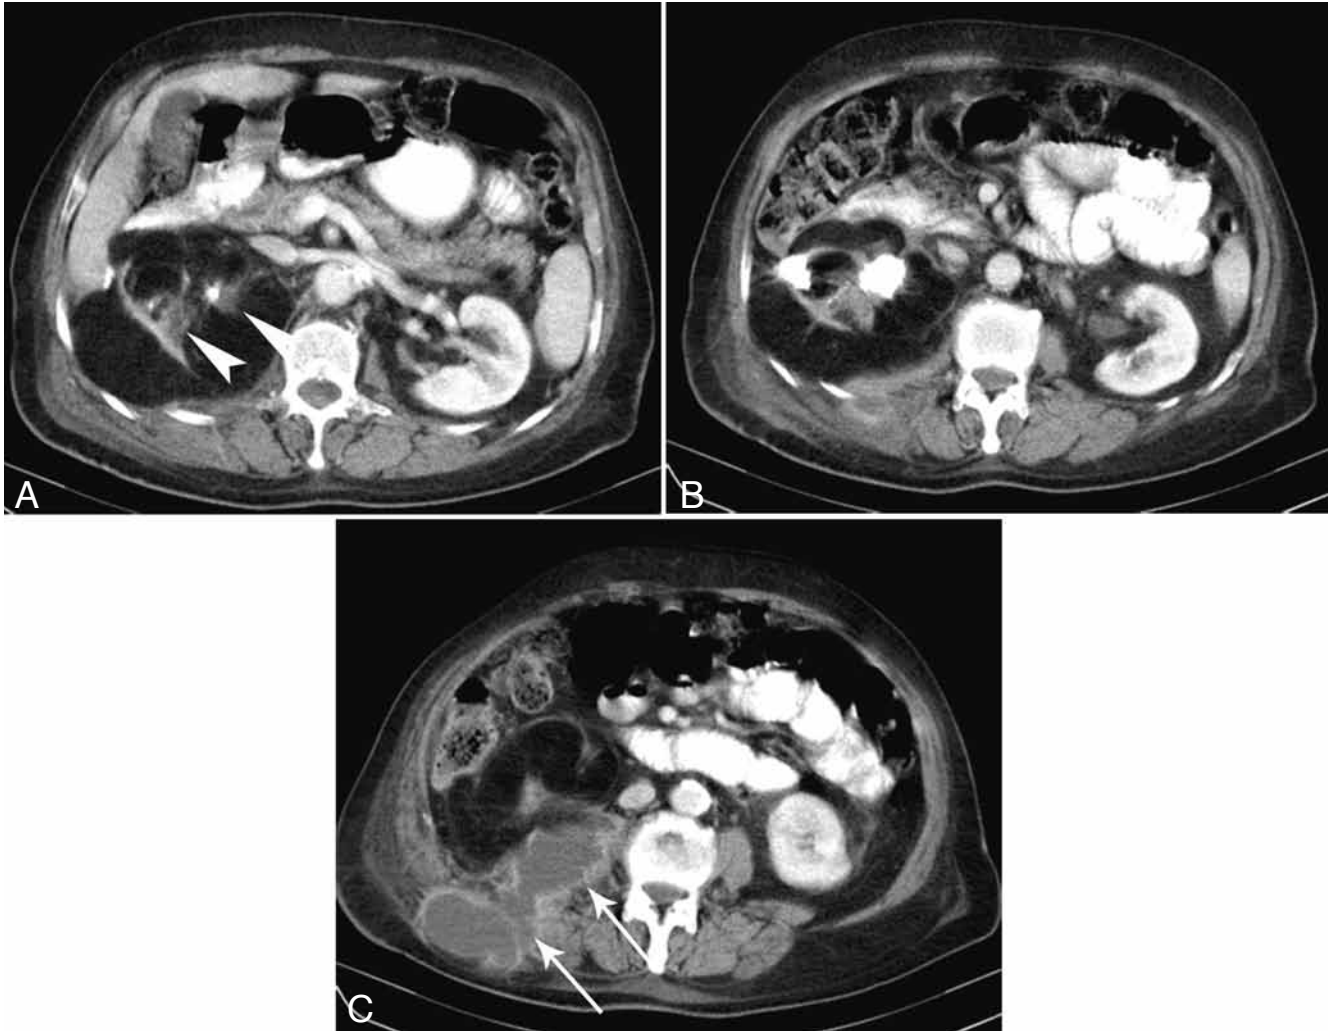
Axial CT image showing significant fatty proliferation of the right renal sinus, hilus, and perirenal space, focal low-density areas (arrowheads) and advanced parenchymal atrophy (A). Central areas of high-density and renal calculi are observable (B). In addition, a broad collection is noticed extending from the right lumbar subcutaneous area into the right perirenal space, demonstrating peripheral contrast attenuation, consistent with abscess (arrows) (C).
